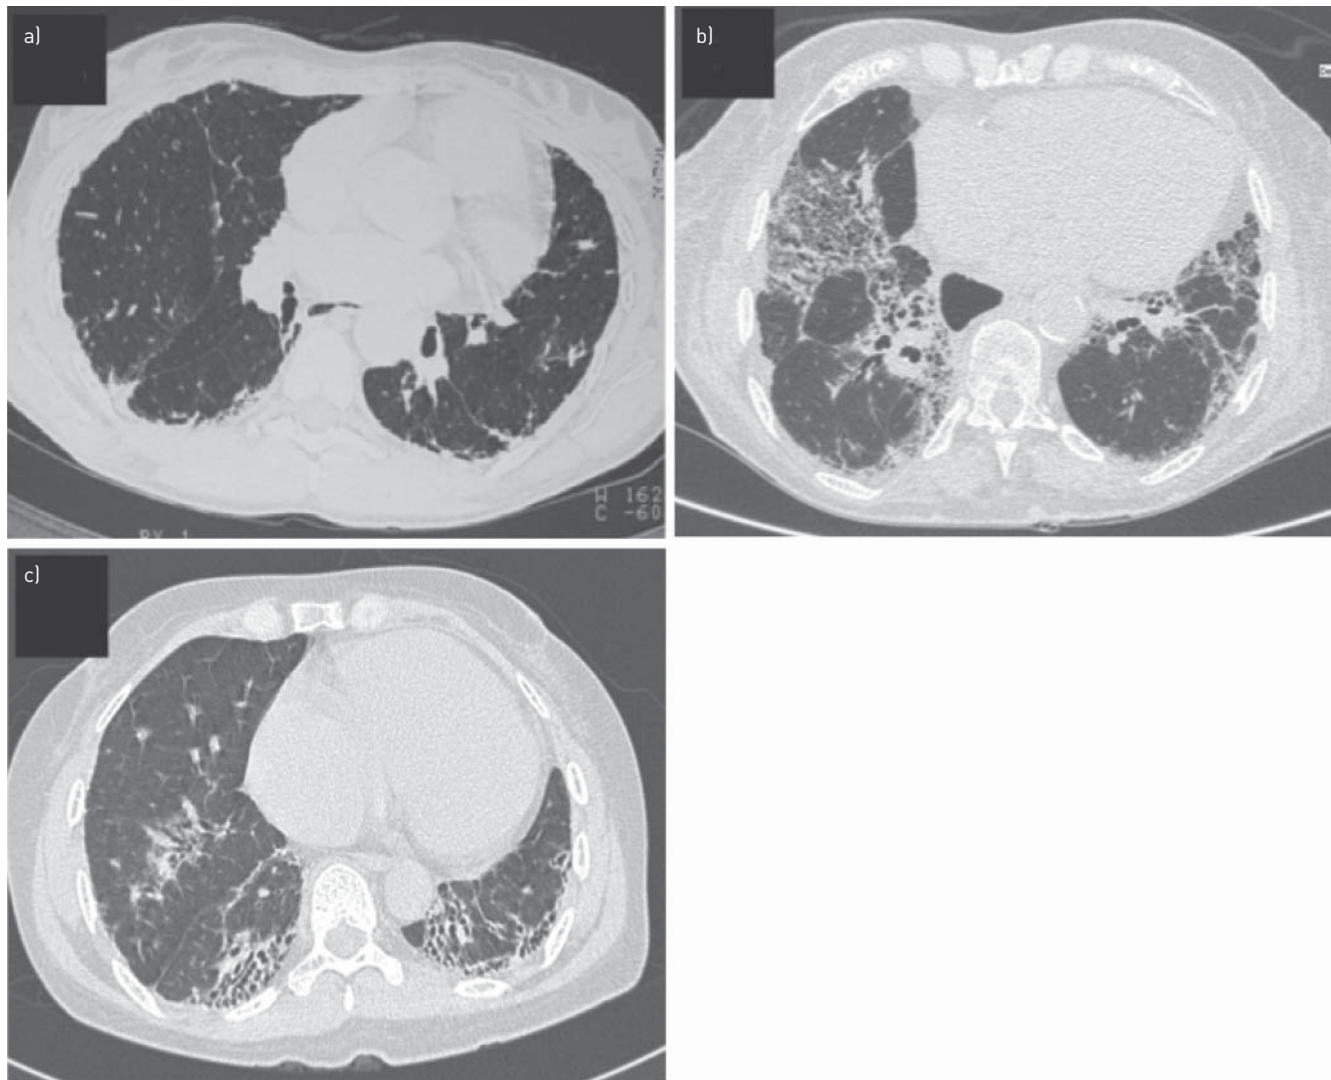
Representative thoracic computed tomography images of the interstitial lung disease (ILD) in patients with severe pulmonary hypertension associated with ILD. High-resolution computed tomography images of the ILD in three different patients, a) patient 10, b) patient 15, and c) patient 16, with a fibrosing nonspecific interstitial pneumonia pattern, showing predominant reticular opacities more or less associated with ground glass opacities and traction bronchiectasis or bronchiolectasis. The lesions were bilateral and mainly localised to the posterior and basal areas of the lungs (lower lobes).
